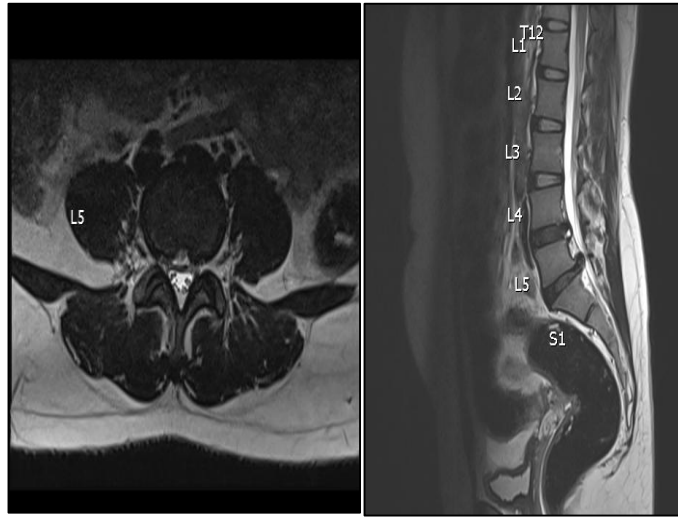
Annular Fissure with Disc Bulge and Disc Extrusion in a 22-Year-Old Female. Sagittal (Right) And Axial (Left) T2-Weighted MRI Images of the Lumbosacral Spine Demonstrate an Annular Fissure (Transverse) with Modified Pfirrmann Grade 5 and Associated Disc Bulge at the L4/L5 Level. Additionally, Modified Pfirrmann Grade 6 with Disc Extrusion Is noted at the L5/S1 Level
